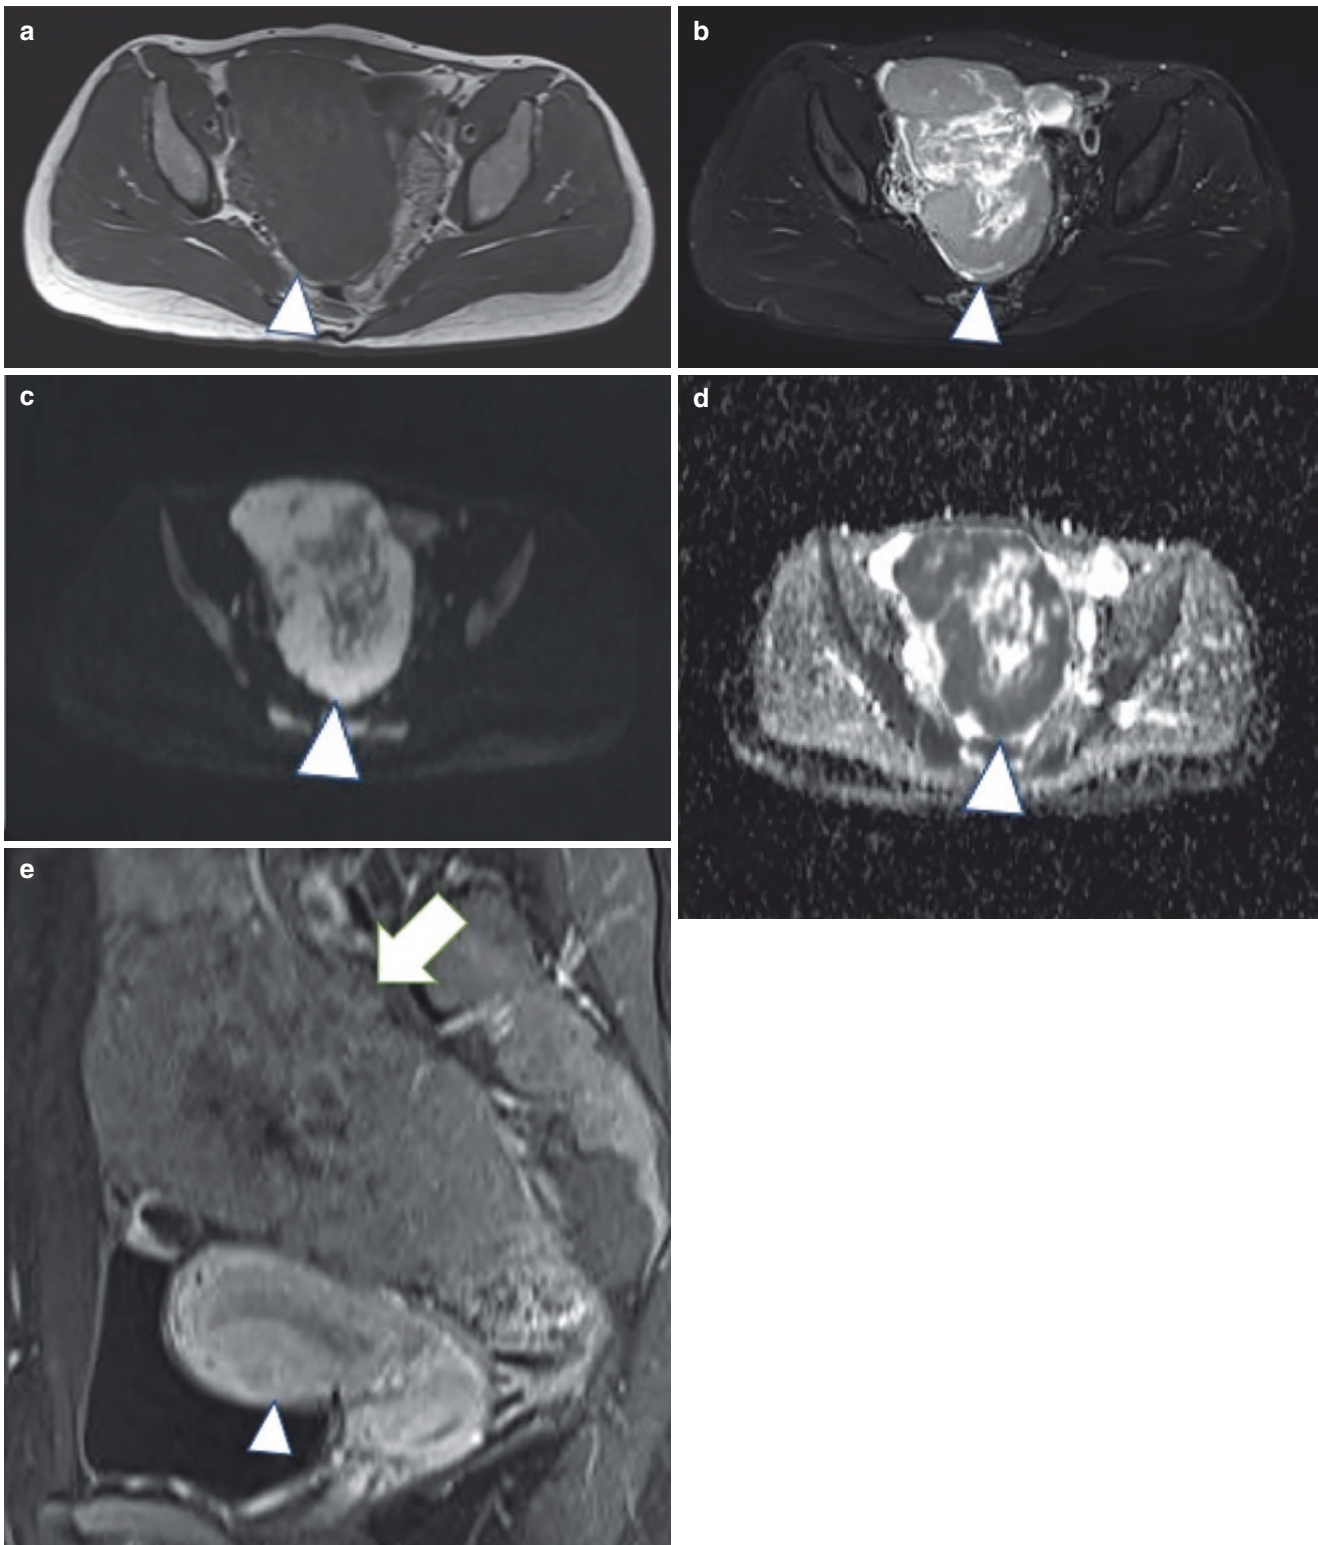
A 21-year-old woman. The patient complained she felt a pelvic mass a decade days ago. Ultrasound examination suggested a solid mass arising from the ovary. CA125: 49.02 U/mL; HE4: 39.6 pmol/L; CA153: 6.40 U/mL; and CA199: <2.00 U/mL, AFP: 1.81 ng/mL. No abdominal pain and distension, fever, abnormal vaginal bleeding, and discharge were reported. The final pathological diagnosis was ovarian
